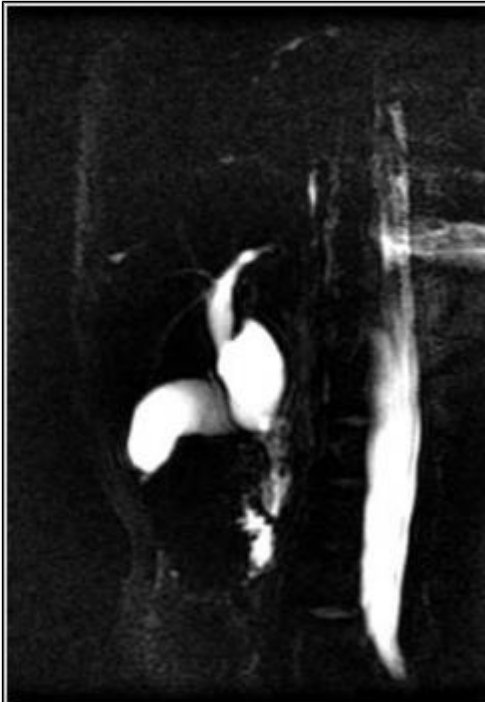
MRI- T2 Coronal
